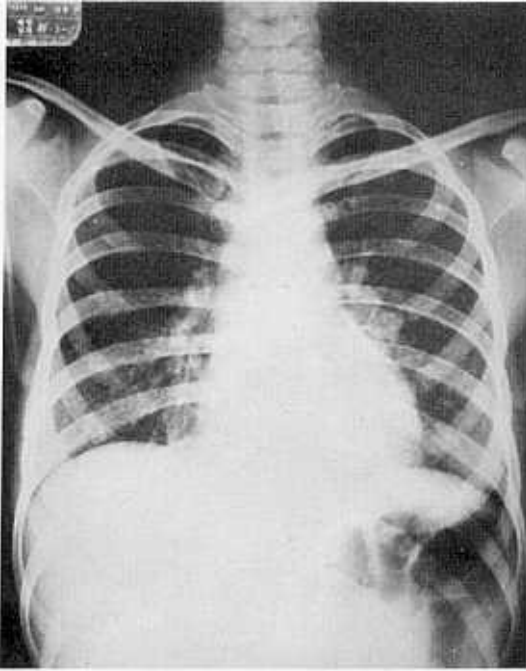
Chest X-ray shows discrete fine nodular and/or mottled densities in both lungs, which is most likely suggestive of miliary tuberculosis.
